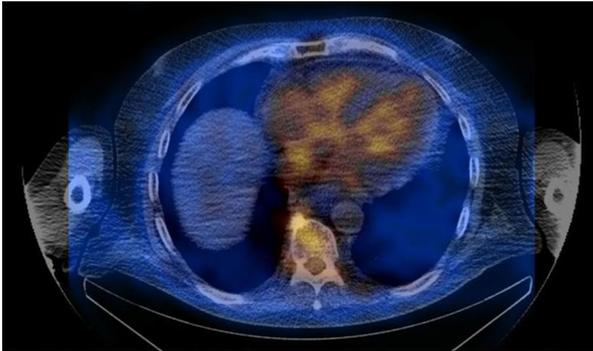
Figure - Fused low dose CT and SPECT scintillation images, with increased activity in the blood pool and cold myocardium.
